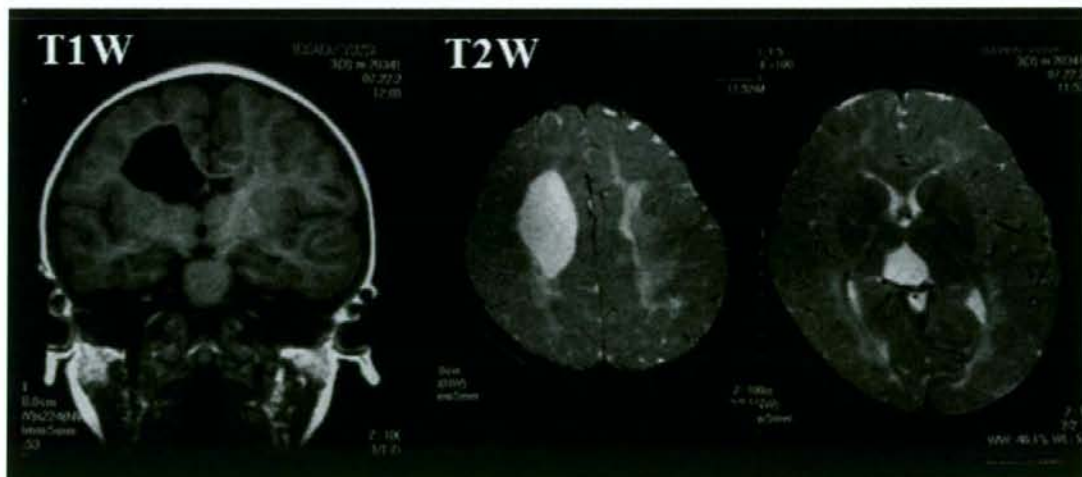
Magnetic resonance images at two y. T1-weighted image shows a subependymal cyst in the right frontal region. Myelination is complete in the T1-weighted image. Myelination is incomplete in the optic radiation and internal capsule in the T2-weighted image.
